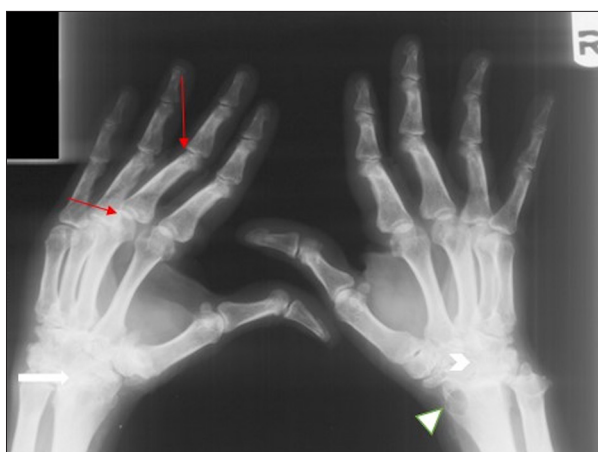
X-radiograph of both hands in a 74-year-old man with Paget disease and rheumatoid arthritis. X-radiograph of both hands shows decreased and irregular joint spaces at the radiocarpal (arrow) and intercarpal joints (arrowhead). Hyperextension of the distal interphalangeal (DIP) joints with flexion of the proximal interphalangeal (PIP) joints (red arrows). Distal radial erosion is present (triangular indicator).
